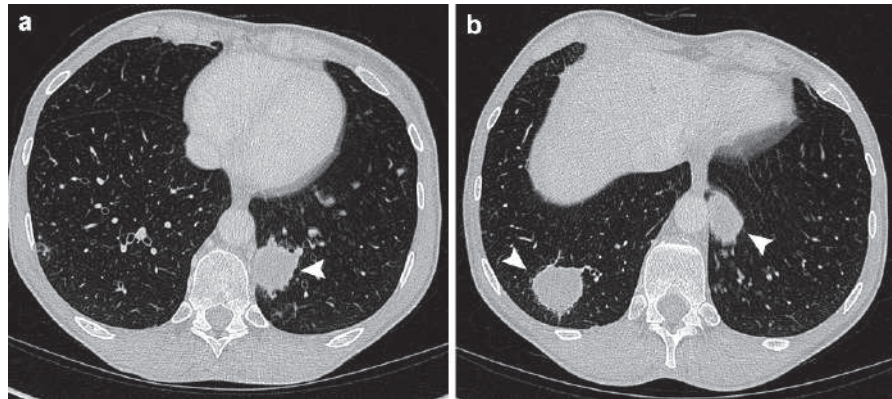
Sequential axial HRCT of a patient with lymphomatoid granulomatosis (LG) shows multiple lung masses located at the lung bases in the left lung in (a) and bilaterally in (b) (arrowheads)
